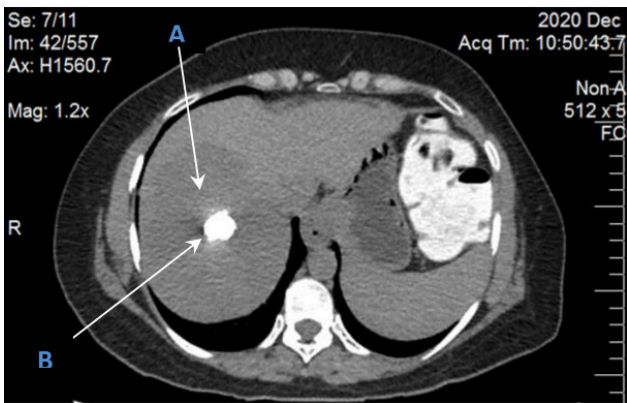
Axial slice of the CT abdomen demonstrates 63 x 8 x 75 mm well-defined lesion in segment VII of liver (A) with 20 x 14 mm calcific focus and area of central non-enhancing necrotic area (B).
